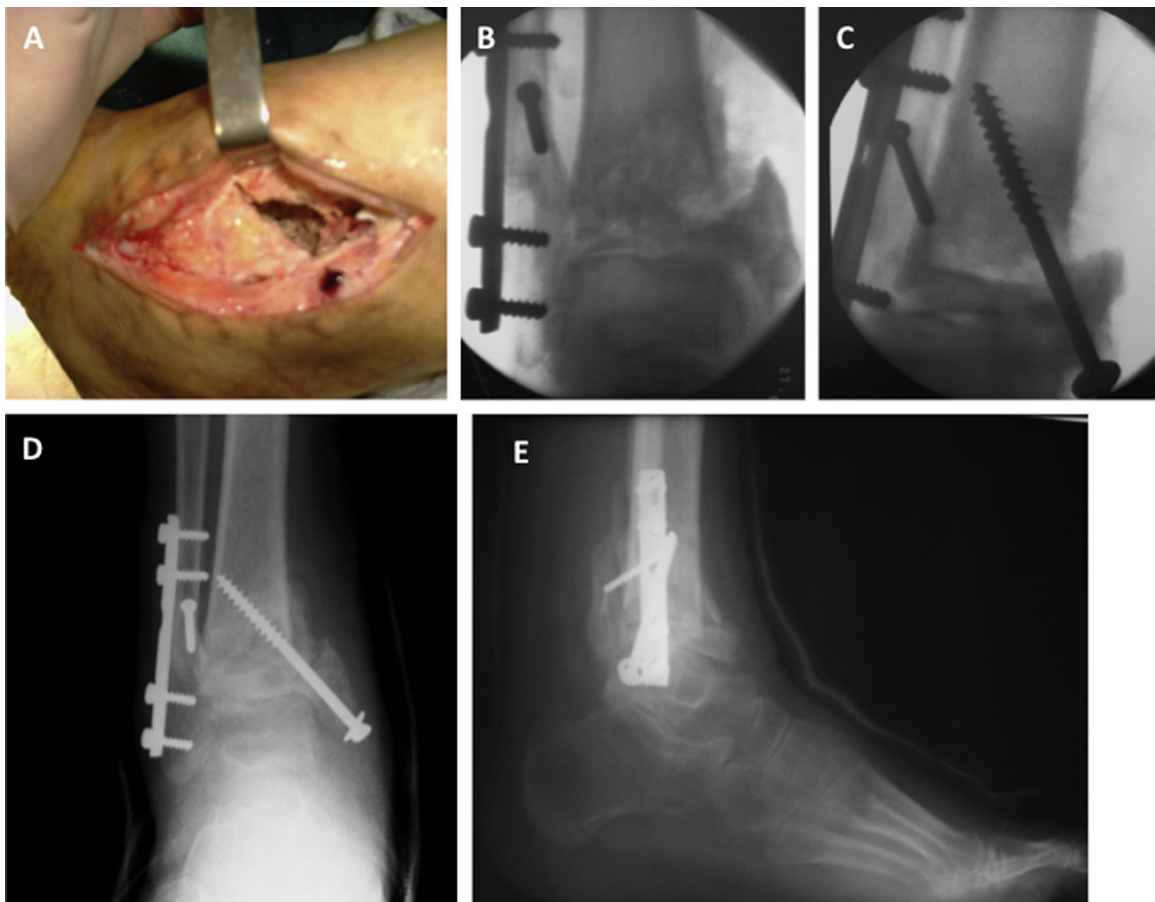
Appearance of the medial ankle joint defect after removal of the implants (A); application of tricortical iliac crest autologous bone grafting (TCG) to the tibial plafond of the ankle joint surface (B); pre-operative fluoroscopy images before and after autografting (C); and anterior–posterior and lateral radiographs in the early post-operative period with cast *in situ* (D, E).
